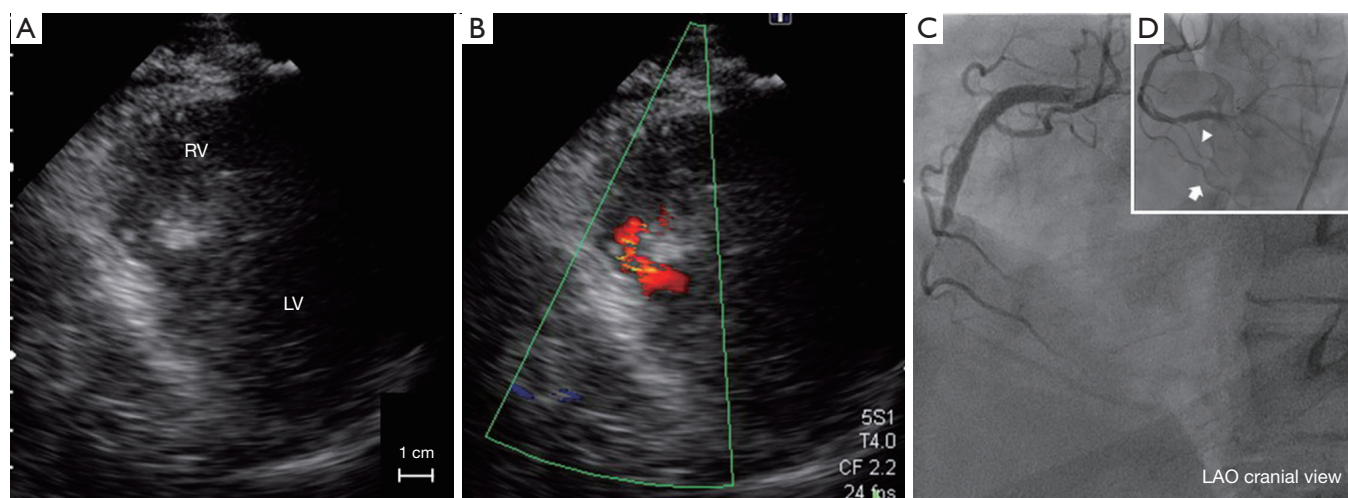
Echocardiography and primary angioplasty. (A) Transthoracic echocardiography in the parasternal short axis view showed ventricular septal perforation measuring 6 mm of the maximum diameter; (B) color flow image showed continuous left to right shunt flow through the ventricular septum; (C) right coronary artery was occluded in the mid portion; (D) final post-stenting angiography resulted in recanalization. Note that flow was preserved in the right ventricular branch (arrowhead) and the acute marginal branch (arrow) after the procedure. LAO, left anterior oblique; LV, left ventricle; RV, right ventricle.
